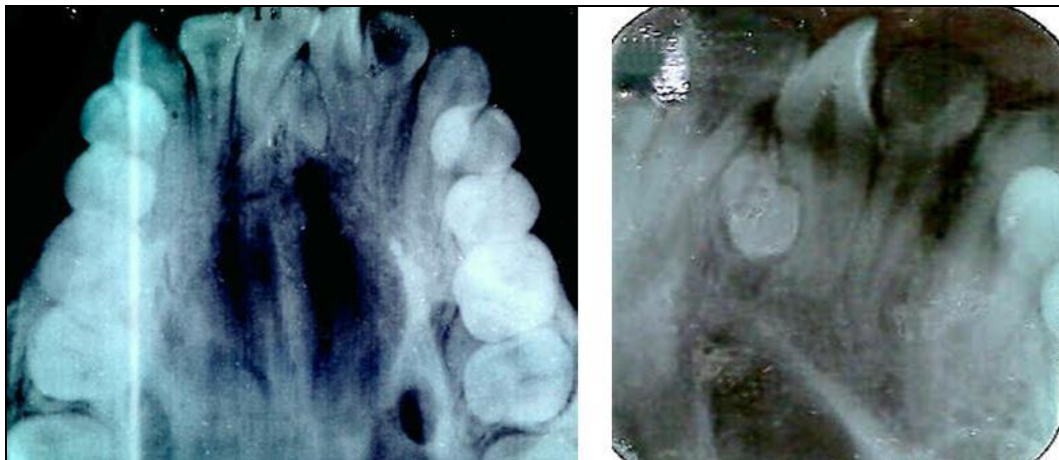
Occlusal and periapical radiograph showing retained mesiodens and its proximity to the roots of the central incisors.
